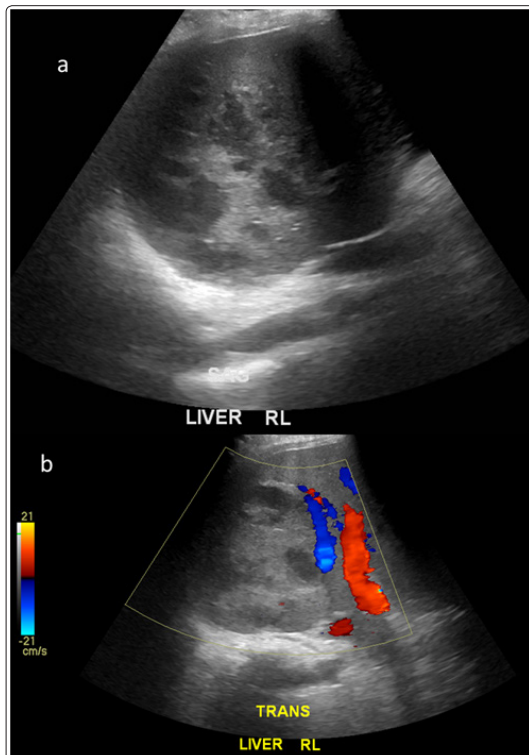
US done on presentation showing ill-defined heterogeneous lesion (Image a & b) with internal anechoic areas represents necrosis, color Doppler (Image b) reveals increase peripheral vascularity, likely abscess, needs further Imaging for better evaluation.
